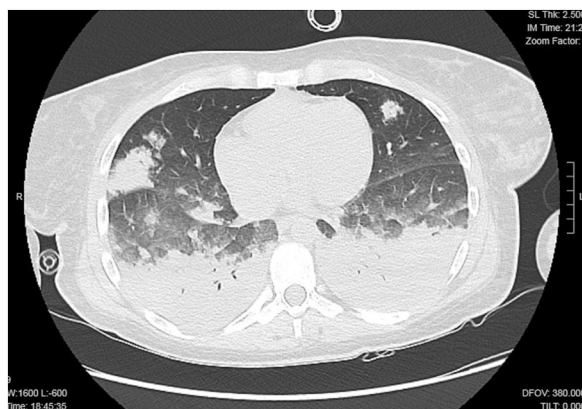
High-resolution computed tomography scan of the chest shows partial resolution of the ground-glass opacities with new consolidation, and bibasal atelectasis."
